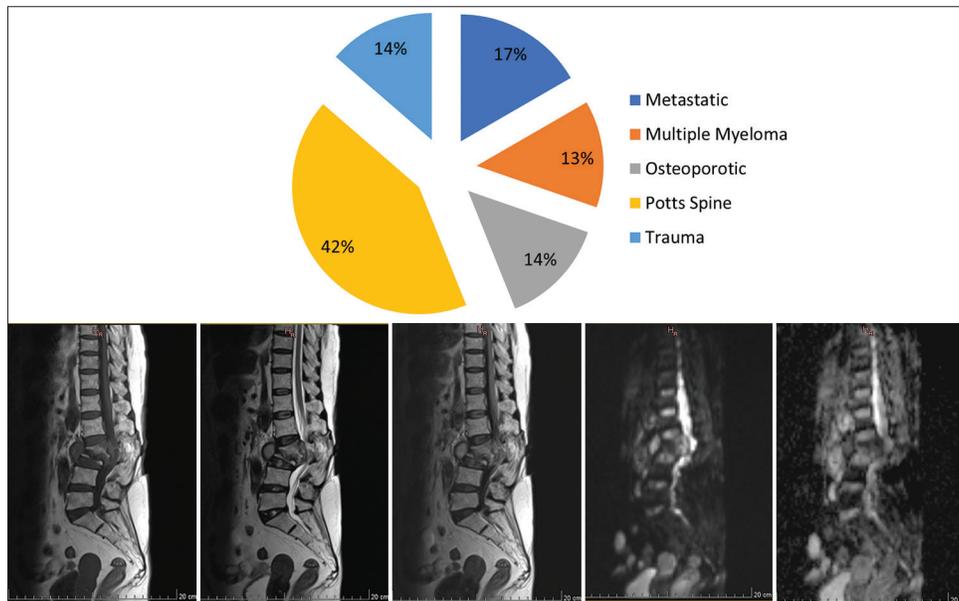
A 62-year-old female patient presented to emergency confirmed as a case of Pott’s spine. On T1WI (a), T2WI (b), and STIR (c) showed altered marrow signal intensities seen as patchy and confluent areas of T1/T2 prolongation involving L2 and L3 vertebral bodies with the destruction of endplates and cortical margins. It also shows the partial collapse of the L2 and L3 vertebra. There is the partial destruction of the intervening disc with a reduction of disc space. The lesion shows diffusion restriction on DWI (d). On ADC map (e), ADC at this level is $1.3 \times 10^{-3} \text{ mm}^2/\text{s}$
